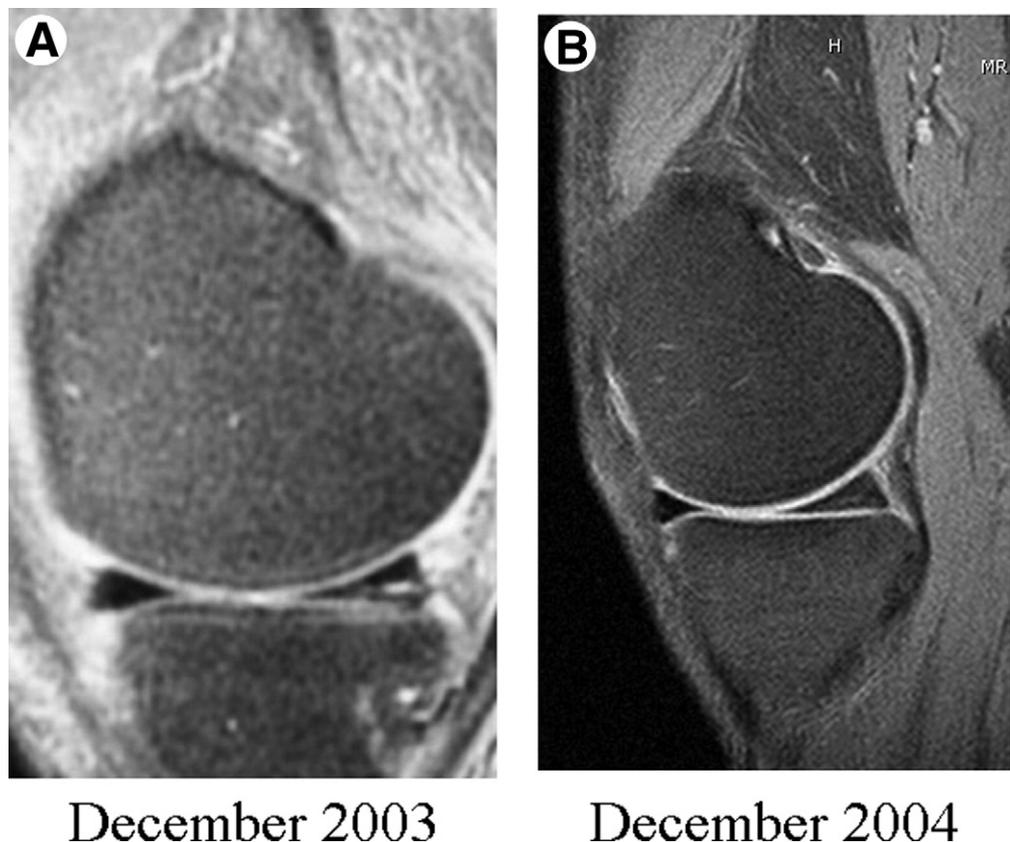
Sagittal proton density, fat saturation MRI of the left knee. (A) (December 2003) A preprolotherapy image showing a high signal in the posterior horn of the medial meniscus indicating a horizontal cleavage tear. (B) (December 2004) A postprolotherapy image showing only mild degenerative signal and no evidence of the previous tear.
